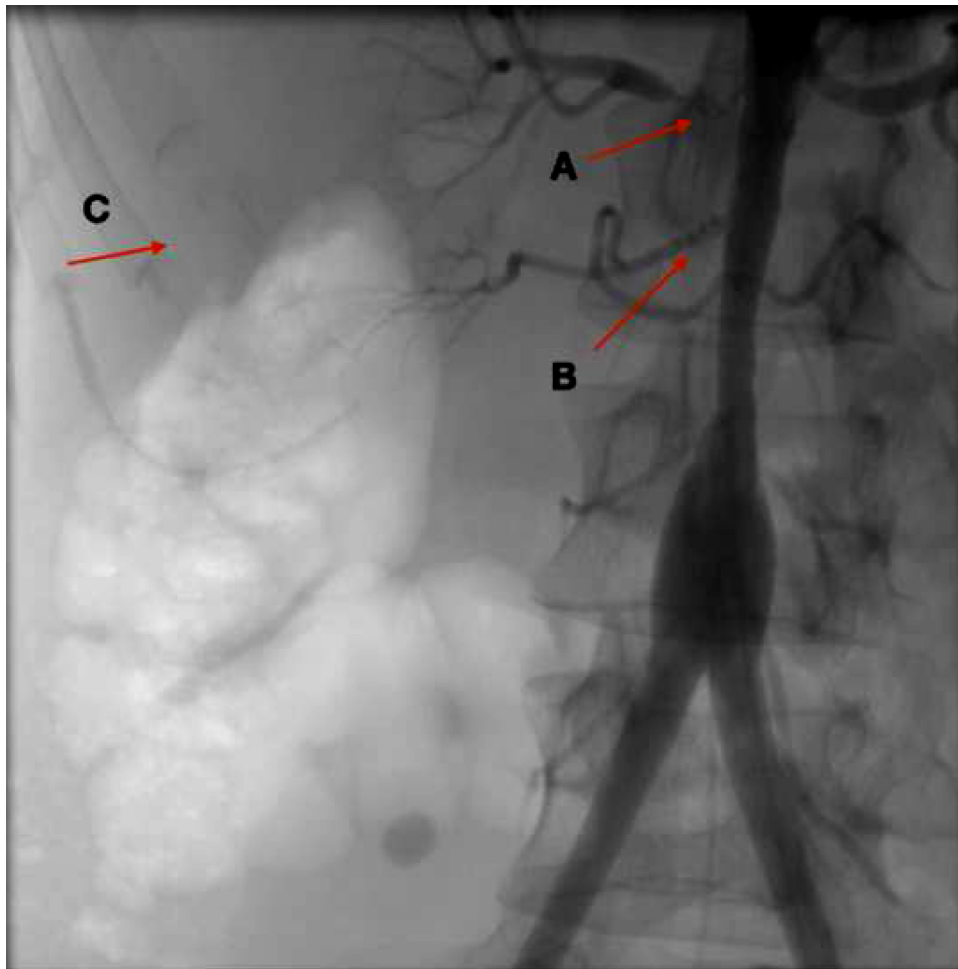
CT Angiography preoperative with evident decrease of vascularization of right kidney.
